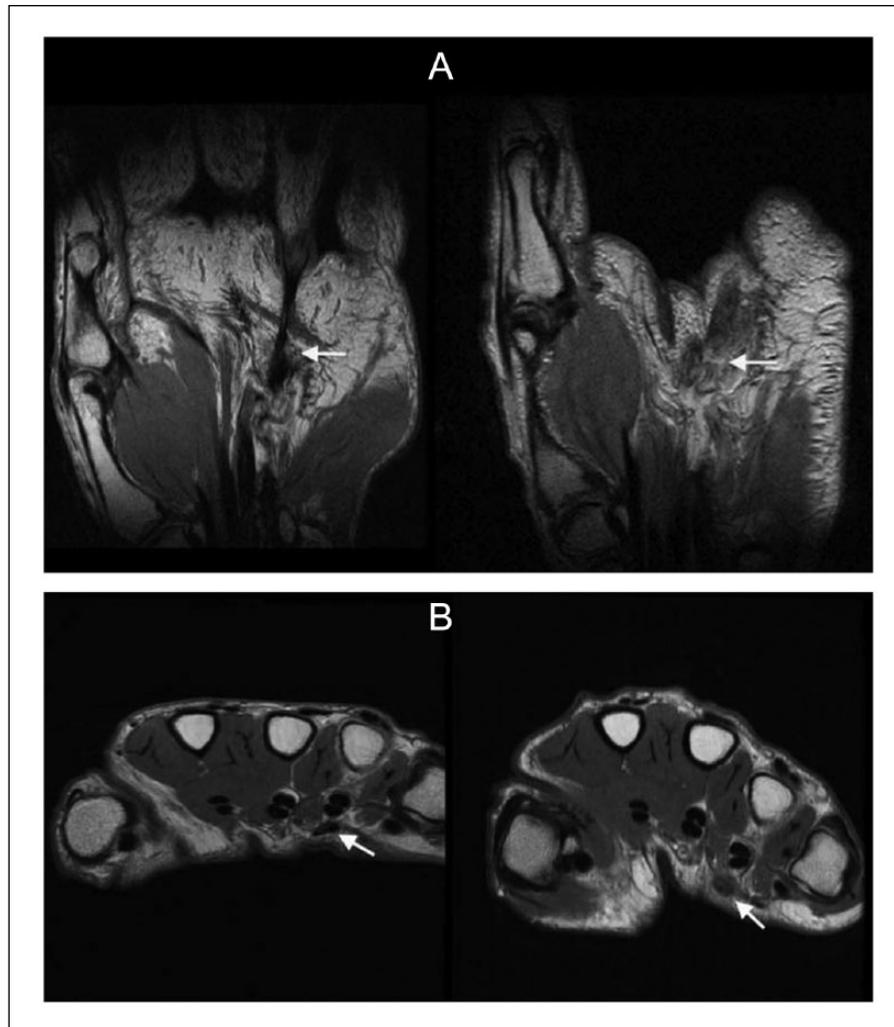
(A) Coronal MRI image demonstrating appearance of Dupuytren's cord before (left) and after (right) collagenase injection and manipulation. (B) Axial MRI image demonstrating appearance of Dupuytren's cord before (left) and after (right) collagenase injection and manipulation.
